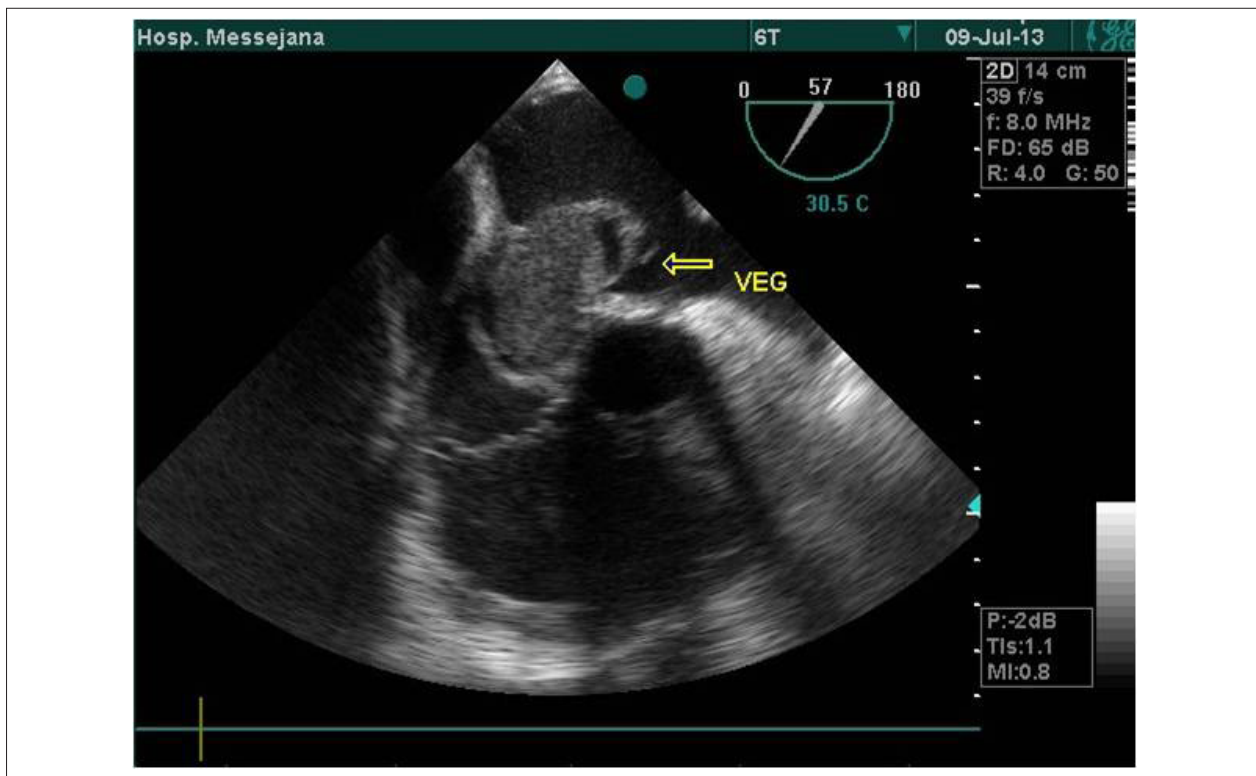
Presence of vegetation in the interatrial septum on transesophageal echocardiography.
